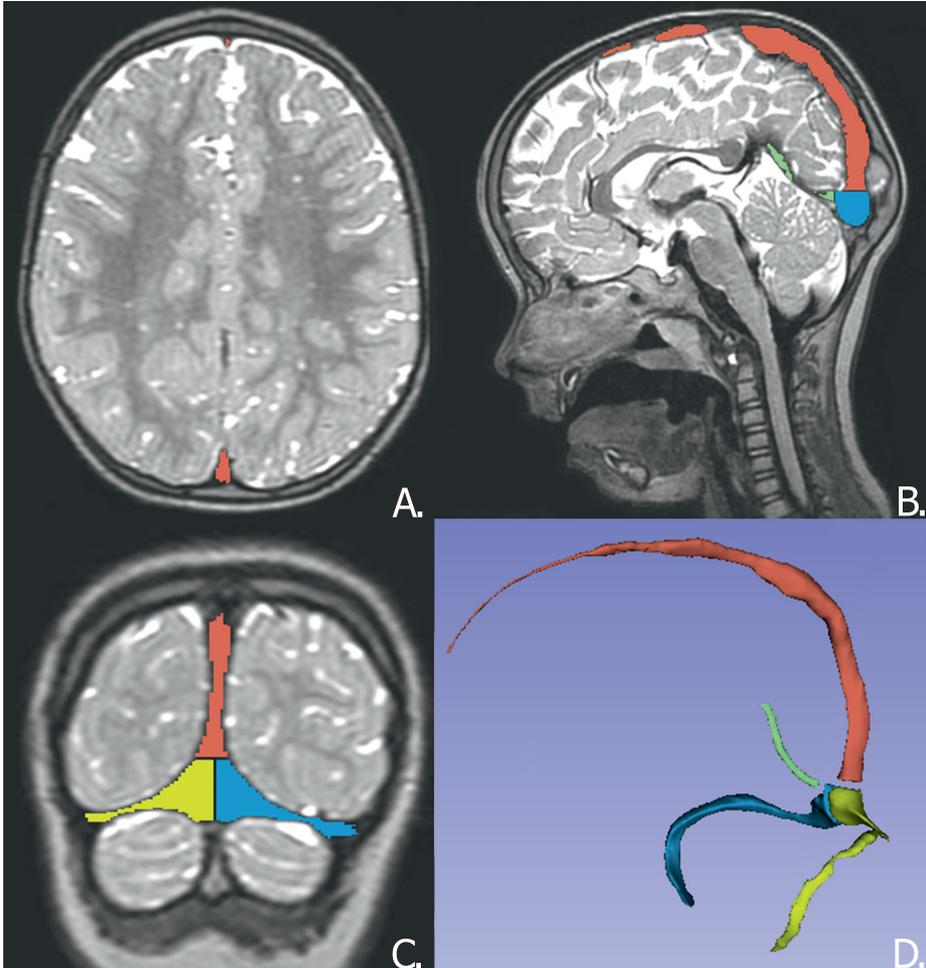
T2-weighted MR images showing the segmentation of the dural sinus volumes. *Red* represents the SSS, *green* the StrS, and *yellow* and *blue* the TSs. A: Coronal image. B: Midsagittal image. C: Axial image at the level of the confluence of sinuses. D: Three-dimensional image of the segmented sinuses.
